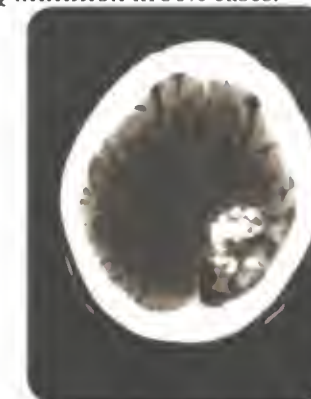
CT scan of the patient shows gyral calcification in the same patient. Patient had epilepsy for more than 10 years
